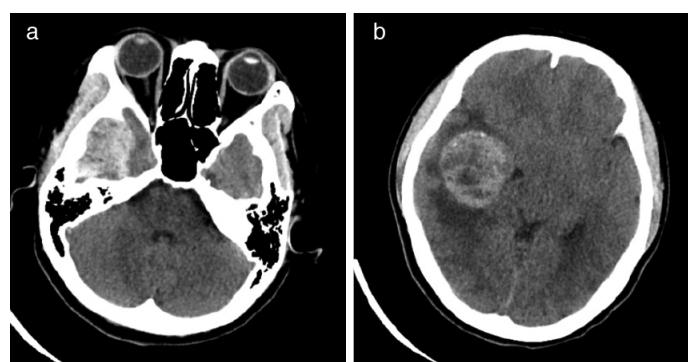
CT revealed circular mixed-density shadows in the right middle cranial fossa and temporal region (1a), with an "8"-shaped lesion surrounded by spotted high-density and massive edema (1a/1b, Axial CT; 1c, coronal CT).
